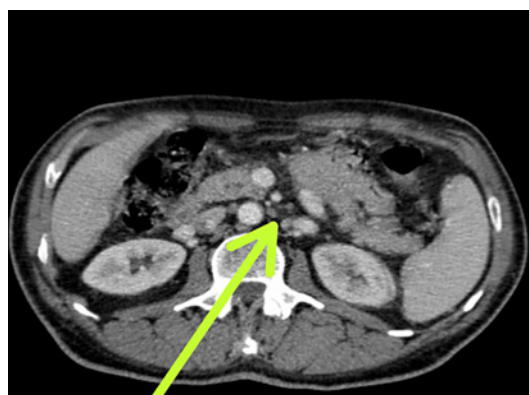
Abdominal CT showing A Complex mass lesion in the tail of the pancreas.
